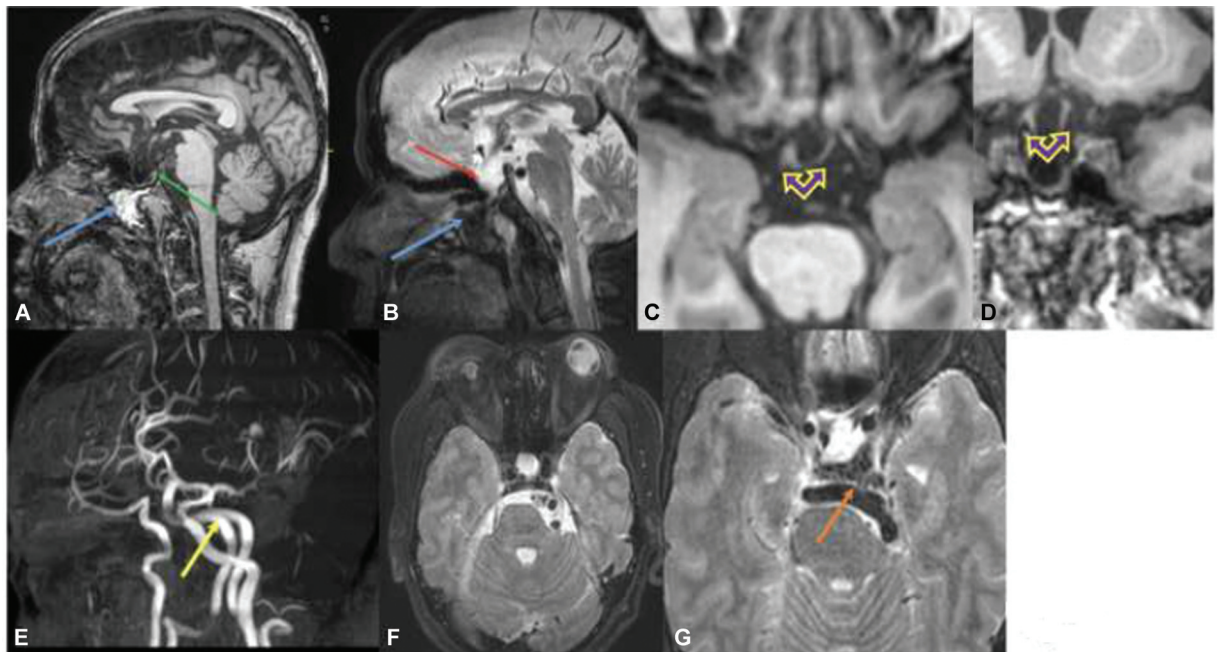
Type 3C persistent craniopharyngeal canal magnetic resonance imaging (MRI), showing sagittal T1 turbo spin echo (Sag-T1-TSE) (A), sagittal T2 fat suppression (Sag-T2-FS) (B), axial T1 (Ax-T1) (C), coronal T1 (Cor-T1) (D), magnetic resonance angiography (MRA) (E), and axial T2 fat suppression (Ax-T2-FS) (F, G). Midline sections in A and B show widened sella containing cerebrospinal fluid (CSF) (red arrow), and an elongated pituitary gland (green arrow) with extension into nasopharynx. T1 hyperintense lesion is seen in the nasopharynx, suppressed on fat-saturated sequence (blue arrow) with isointense soft tissue in the posterior wall of the sac, consistent with dermoid. Abnormal redundant partial fused atrophic optic chiasm (double violet arrow) is seen. MRA (E) shows dolichoectatic vertebra-basilar system (yellow arrow) with high basilar bifurcation (orange arrow, G).
